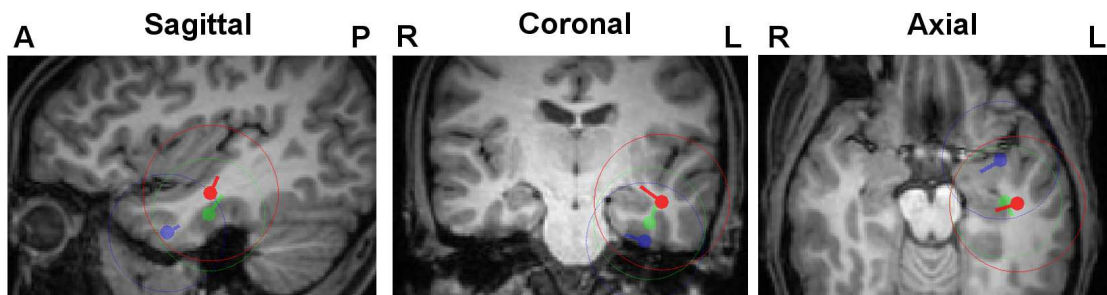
Differences of EEG, MEG and EMEG localizations. FT9 centroids and spread spheres plotted on T1-MRI for EMEG (red), MEG (green) and EEG (blue) using head model $6C_{Cal}$. The centroid location of the combined reconstruction was used for the selection of MRI slices and all results were projected on these slices.
